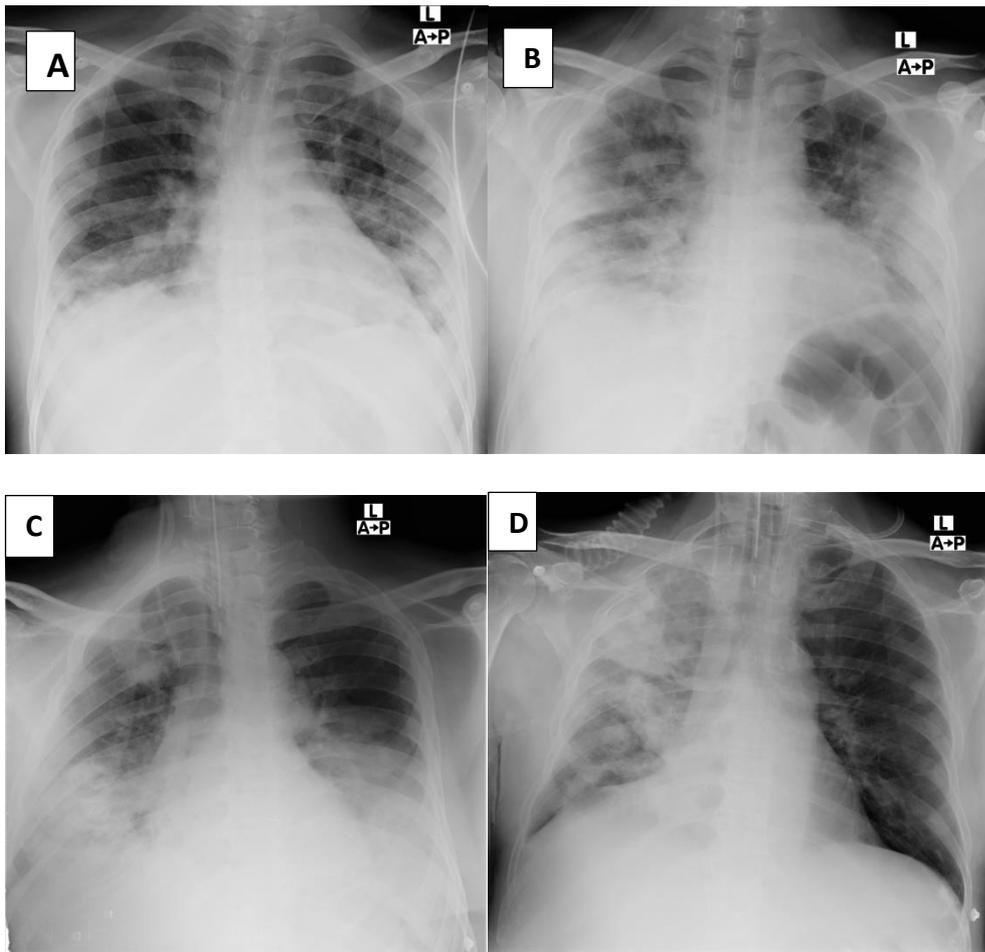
Chest x-ray findings of COVID-19: (A) Bilateral patchy consolidations in mid to lower zones (B) Bilateral consolidations and ground glass opacifications involving upper, mid and lower zones (C) Diffuse consolidations in bilateral lower zones (D) Asymmetrical involvement of lungs with predominantly right side involvement with consolidations and ground glass opacification.
